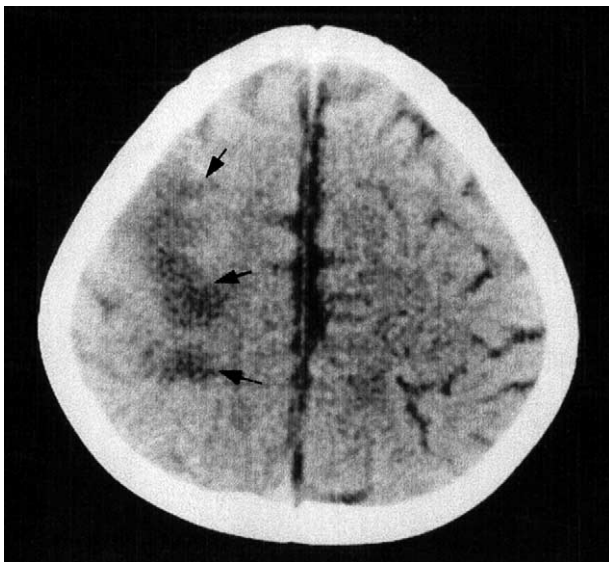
Axial CT scan obtained 2 days after the neurological symptoms. Low intensity areas in the cortex and subcortical white matter involving the right frontoparietal region (arrows). Note the hypodensity is not confined to an arterial territory.
